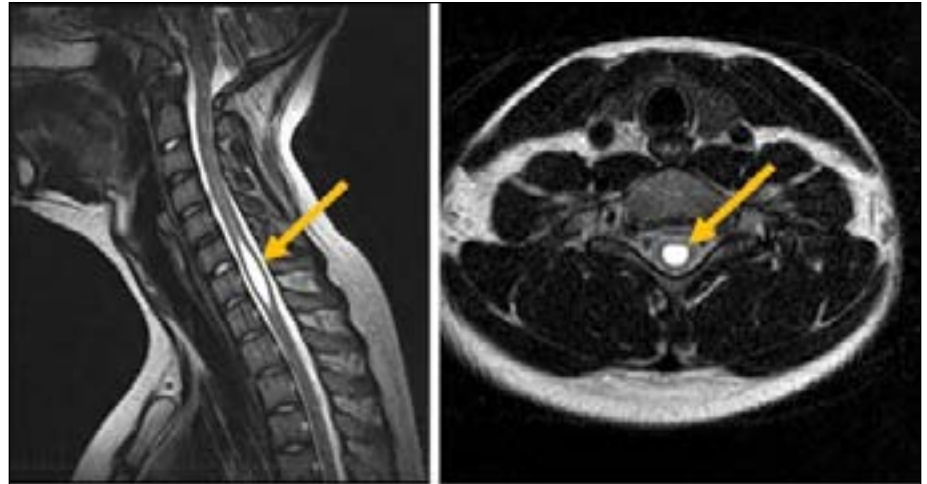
(left) Sagittal MRI Showing Syrinx; 16b (right) Axial MRI Syrinx
